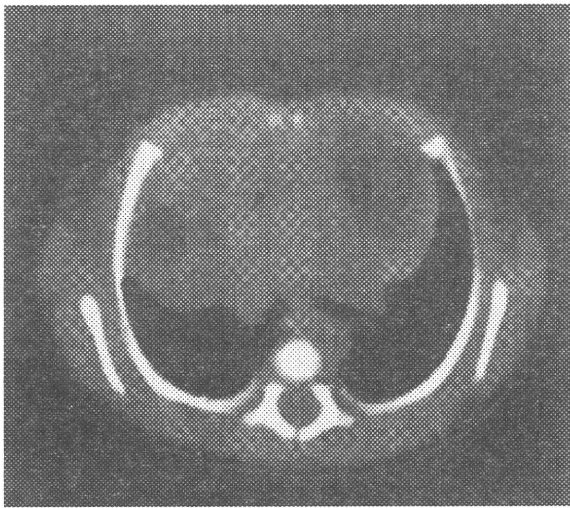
Precontrast chest CT scan at 27 days after birth. The fat attenuation and calcification (arrowhead) became more obvious in the mass.
